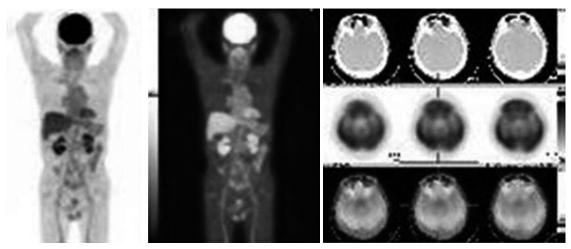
On whole body PET/CT, there was no shown the hypermetabolic lymph nodes.
